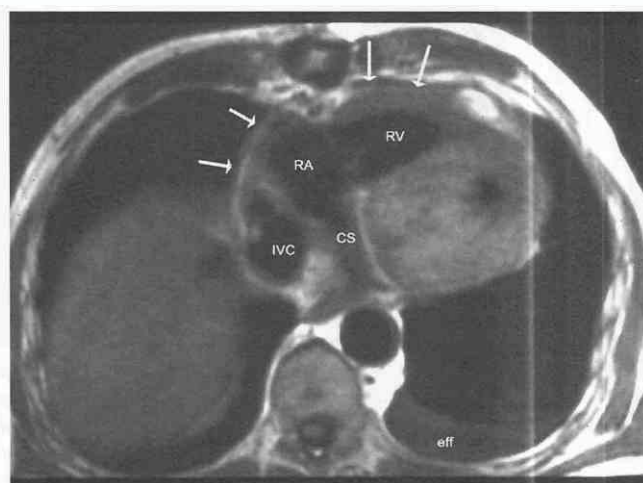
MR image obtained from a 68-year-old man, 8 years after coronary artery bypass surgery, who is now complaining of shortness of breath. There is a left pleural effusion (eff). Thickened pericardium (arrows) surrounds the lateral aspects of the right atrium (RA) and the anterior aspect of the tubular right ventricle (RV). The coronary sinus (CS) is mildly dilated. IVC, inferior vena cava.
